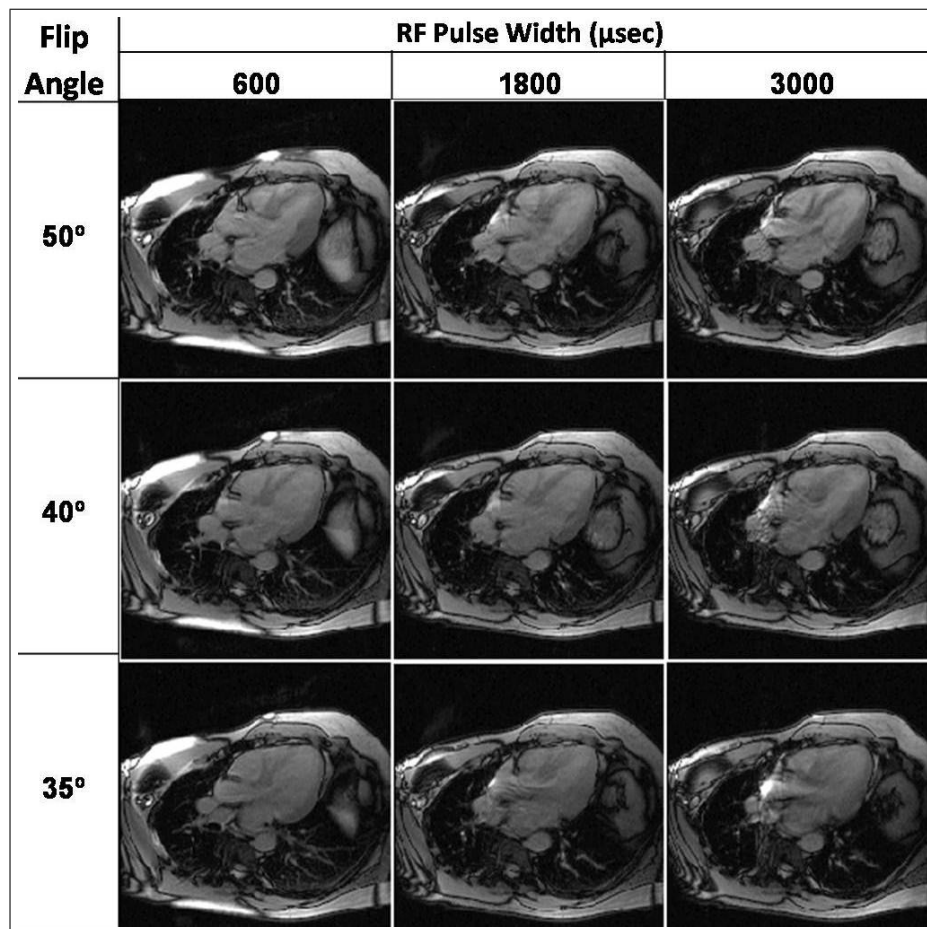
MRI heart images of healthy volunteers were acquired using a bSSFP sequence with flip angle 50,40, and 35 and RF pulse width 600 μsec , 1800 μsec , and 3000 μsec .
